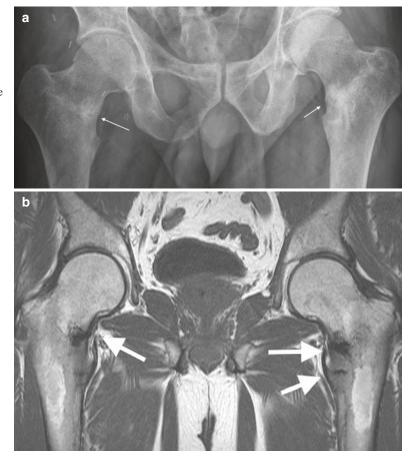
Oncogenic osteomalacia. (a) AP radiographs of the hips with bilateral looser zone-type fractures (*arrows*) and (b) corresponding MRI, Cor T1 demonstrating fracture lines (*arrows*). Octreotide scan-positive primary lesion (not shown)
